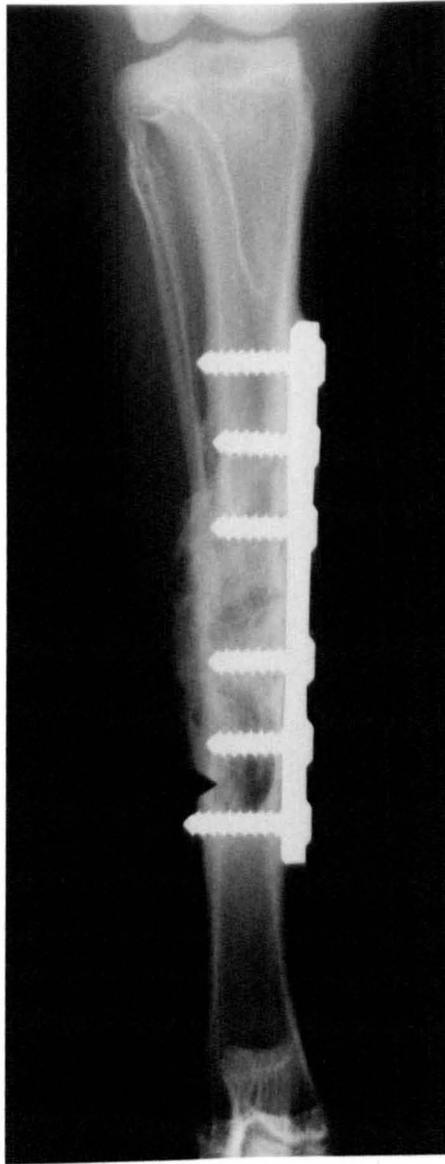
There is osteolysis around the distal screws in this radiograph, obtained eight weeks after fracture and inoculation with bacteria.
